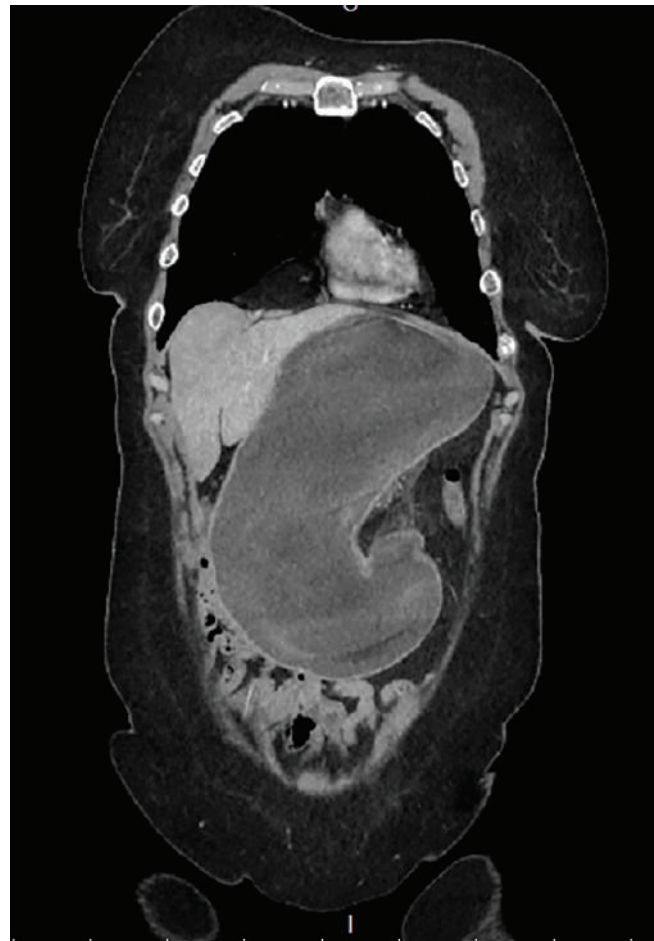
CT image showing gastric volvulus.
